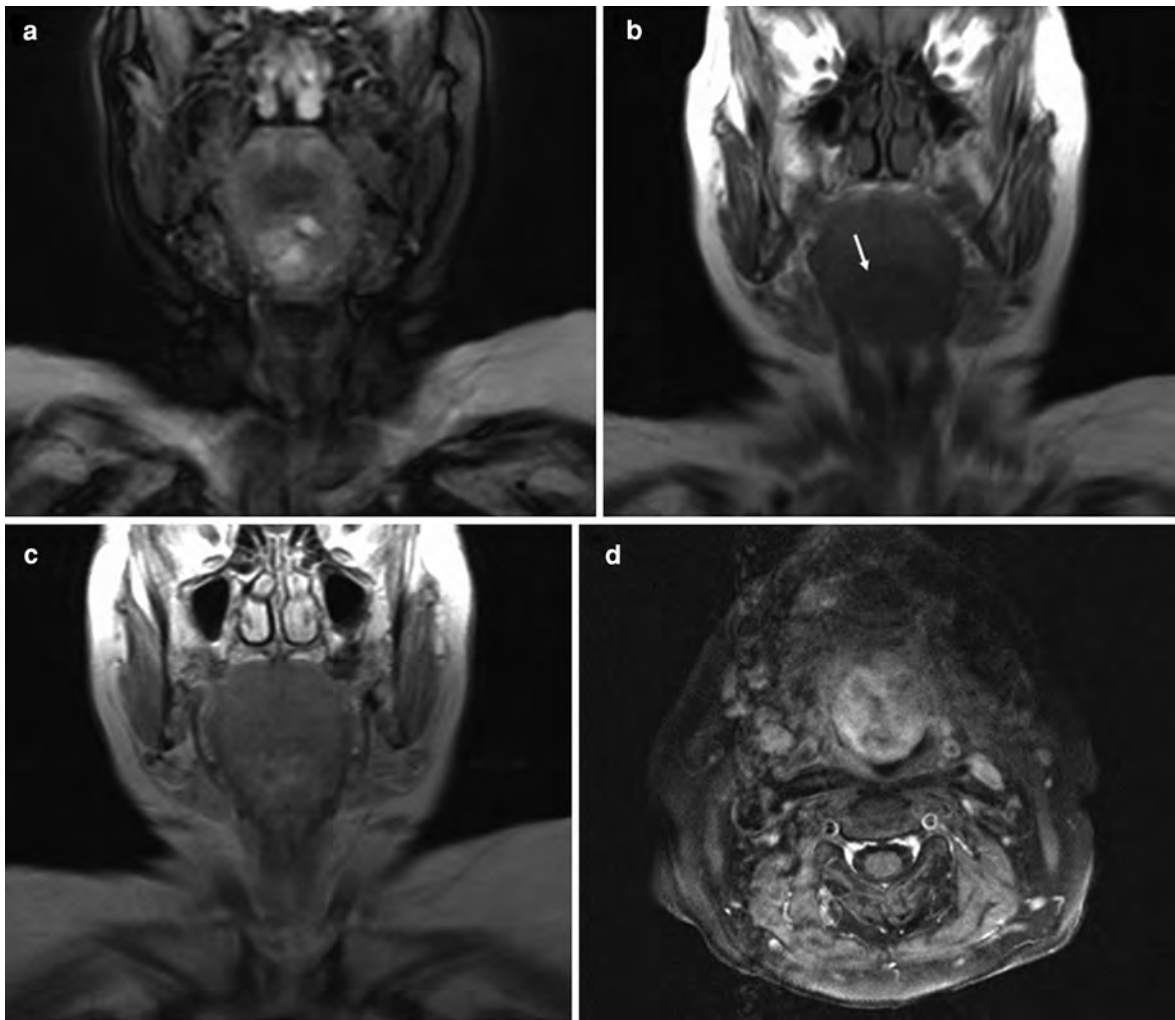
MRI of a 65-year-old female with a large lingual thyroid affecting the tongue as well as the floor of the mouth. The T2-weighted image (a) reveals an inhomogeneous mass with some very hyperintense cysts. On the native T1-weighted image, the mass is slightly hypointense compared to the tongue (b). After contrast agent has been given, the respective coronal
